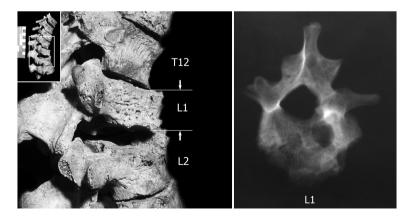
Lytic lesions at the spine (case 2). A: Lateral view (right) of a dorsolumbar segment of the spine (T11-L3) showing loss of body height of L1. B. X-ray (superior) view of L1. A radiolucent region that corresponds to a multilobulated cavity located inside the vertebral body.
